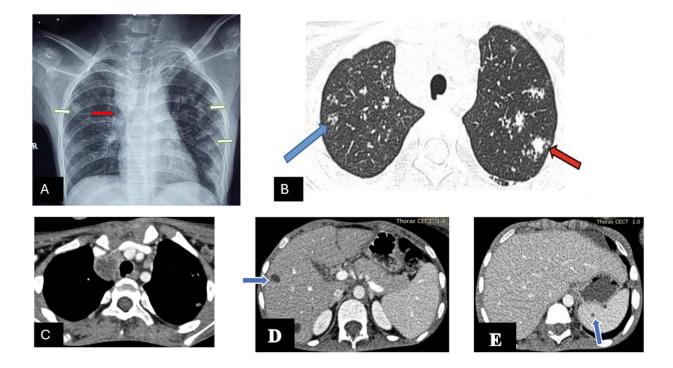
Chest Imaging (CR and CT scan) in CNS TB -In a patient of TB meningitis (CSF CB NAAT was positive for TB) Chest radiograph (A) shows infiltrative lesions in right and left upper zone; and mid zone (white arrows) with widened right paratracheal stripe (red arrow), suggestive of lymphadenopathy. The findings were confirmed on CECT chest requested, showing (B) tree-in-bud nodules in right (blue arrow) and confluent tree in bud nodules in left (red arrow) upper lobe.; with (C) matted, necrotic right paratracheal nodes (blue arrow). Incidental hypodense sub-centimeter granulomas seen in (D) liver and (E) spleen (blue arrows). So, the final diagnosis was Disseminated TB.
